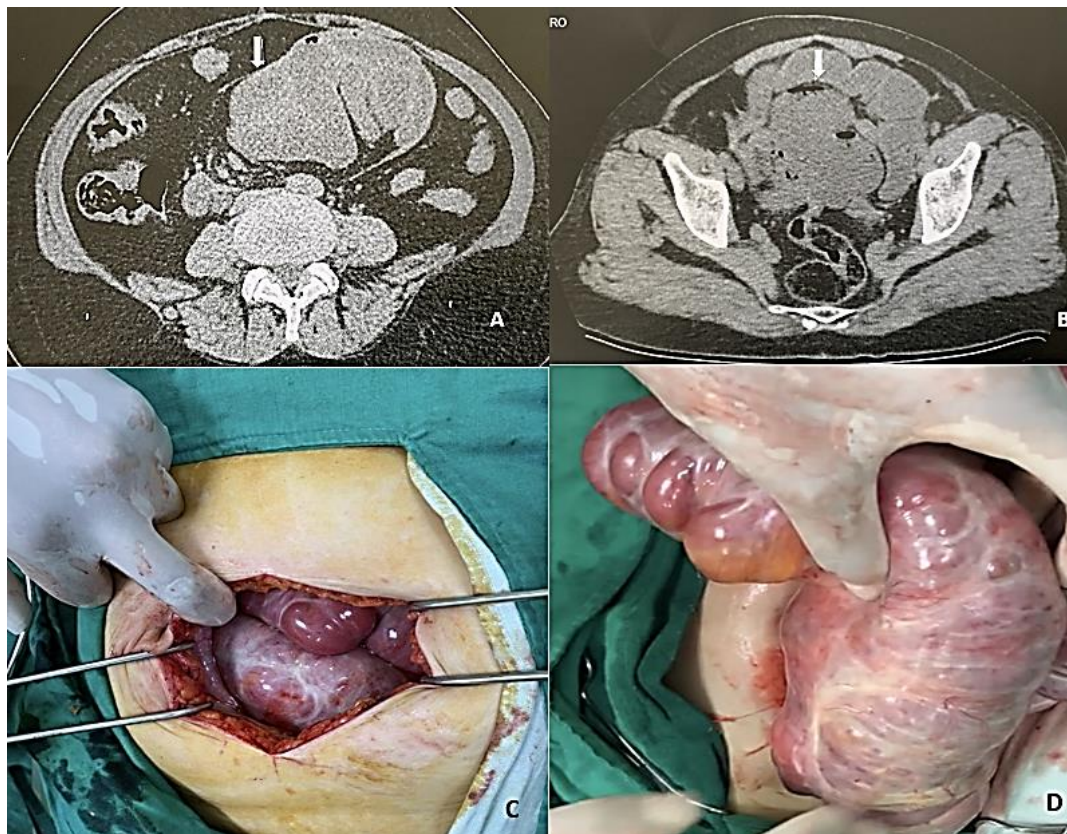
Figure A & B: CT scan images showing the fibrocollagenous membrane encapsulating intestines;
